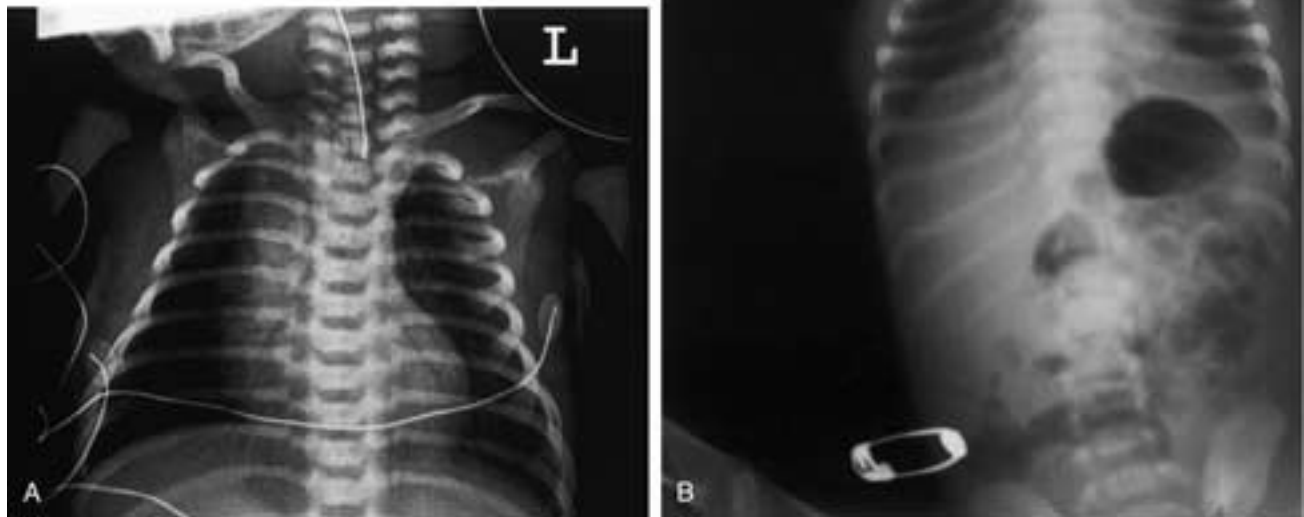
Tracheoesophageal atresia. A, Multiple attempts to pass a nasogastric tube were unsuccessful in this full-term infant with esophageal atresia. The level of the nasogastric tube tip marks the level of the atresia. B, Chest X-ray from a different infant demonstrates a coiled nasogastric tube in the cervical esophagus, with contrast filling the proximal esophageal pouch (arrow). This premature infant presented with copious oral secretions and noisy respiration. Gas within the bowel indicates a distal communication between the tracheal bronchial tree and the gastrointestinal tract.
